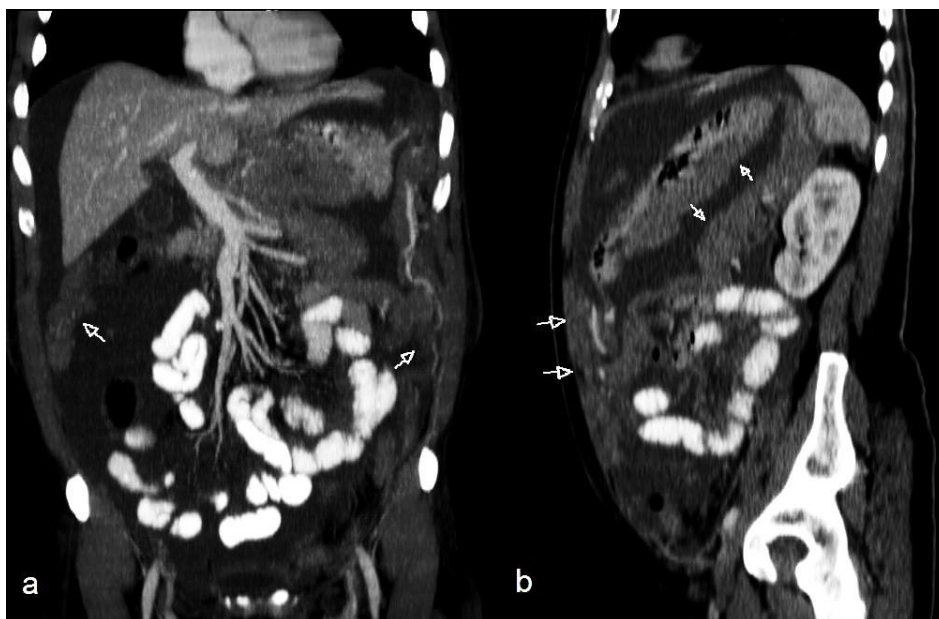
Sixty-one-year-old male with Burkitt lymphoma. Multiplanar reconstruction in the coronal a) and sagittal b) plan of a contrast enhanced CT of the abdomen and pelvis in the portal phase (Scanner: Multidetector CT Philips Brilliance 16-slices®. Protocol: 250mAs, 120kV, 5mm slice thickness, 100ml iobitridol Xenetix® (350 mg Iodine/ml)). There is a diffuse nodular heterogeneous thickening of the peritoneum (arrows) and low attenuation free peritoneal effusion; no enlarged lymph nodes were noted.
